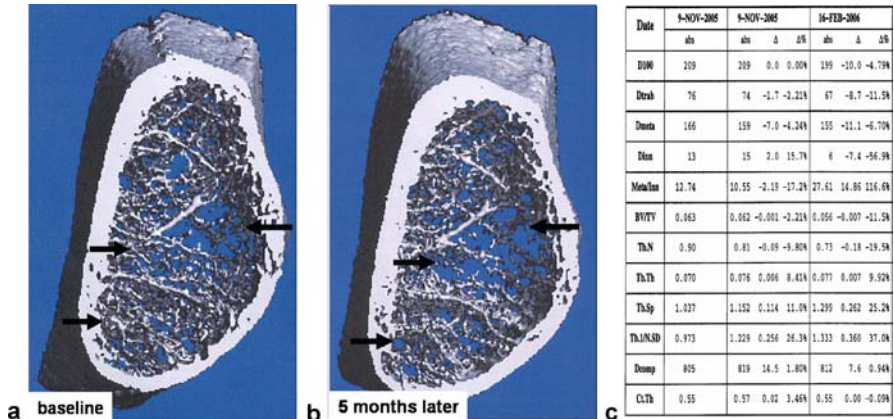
The Xtreme-CT: monitoring of trabecular bone loss of at distal radius of a post-menopausal women. a A 3D distal radius at baseline (arrows). b A 3D distal radius of the same region made 5 months after baseline measurement (arrows: demonstrating trabecular bone structural deterioration and loss). c Datasheet for comparison of density and structural values
